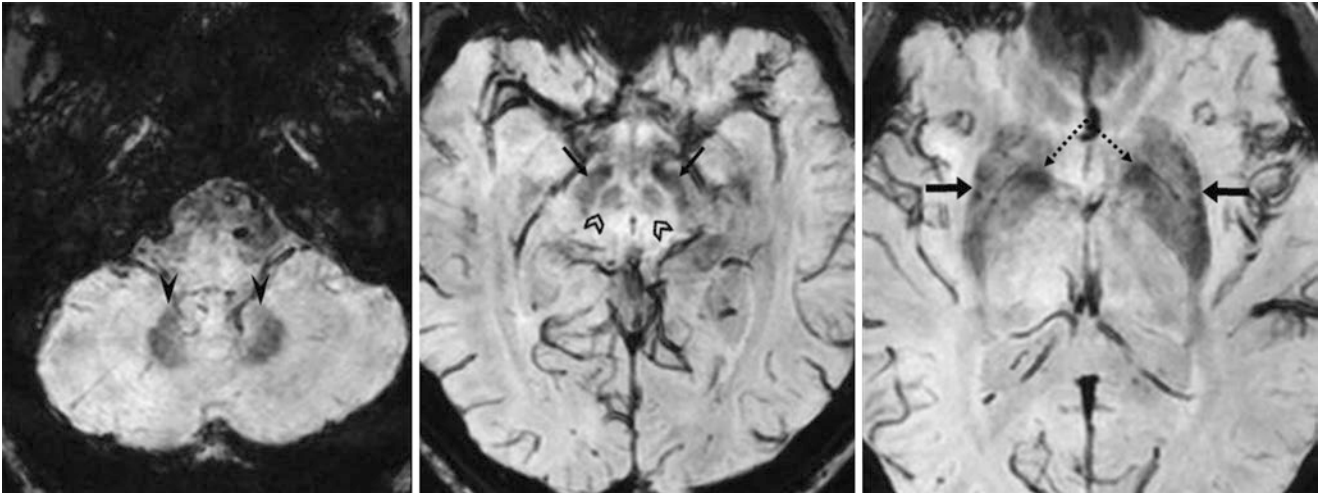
A 40 year old with a negative 3T MRI performed for seizures. SWIs depict iron deposition within the dentate nuclei (*arrowheads*), SN (*thin arrows*), GP (*dotted arrows*), red nuclei (*chevrons*), and putamina (*arrows*). The putamina have darkened in signal, particularly more laterally
